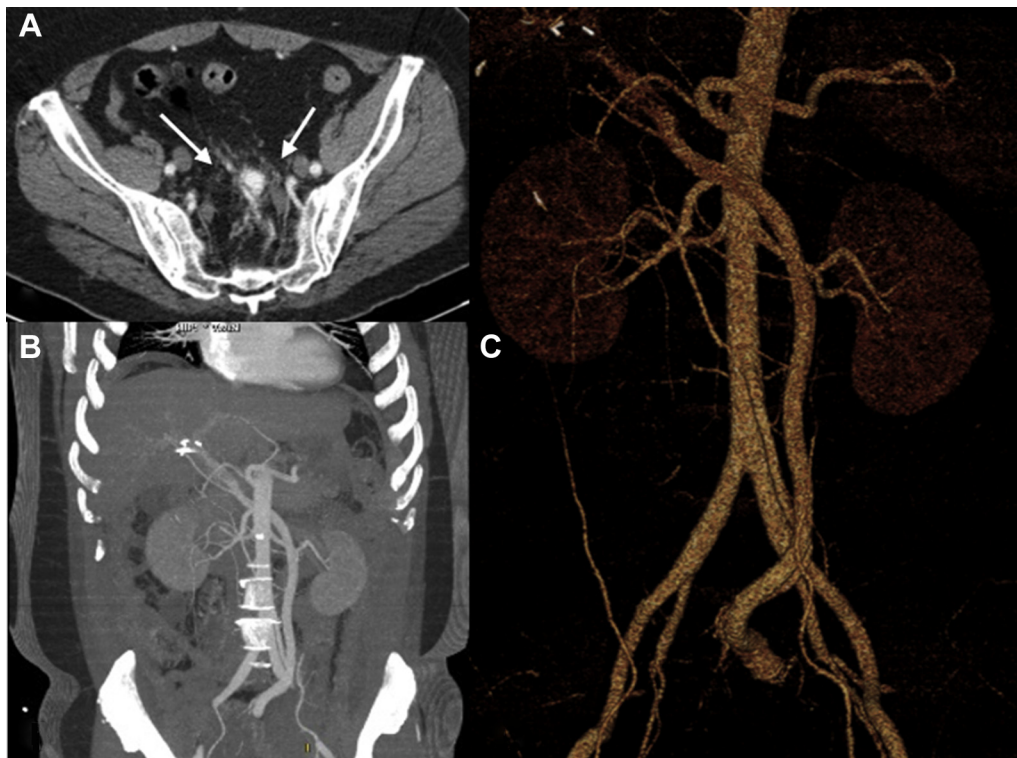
Computed tomography (CT) angiography demonstrates the inferior mesenteric artery (IMA) with irregular filling of the inferior mesenteric vein (IMV; *arrows*). A, Axial view. B, Coronal view. C, Three-dimensional reconstruction.
